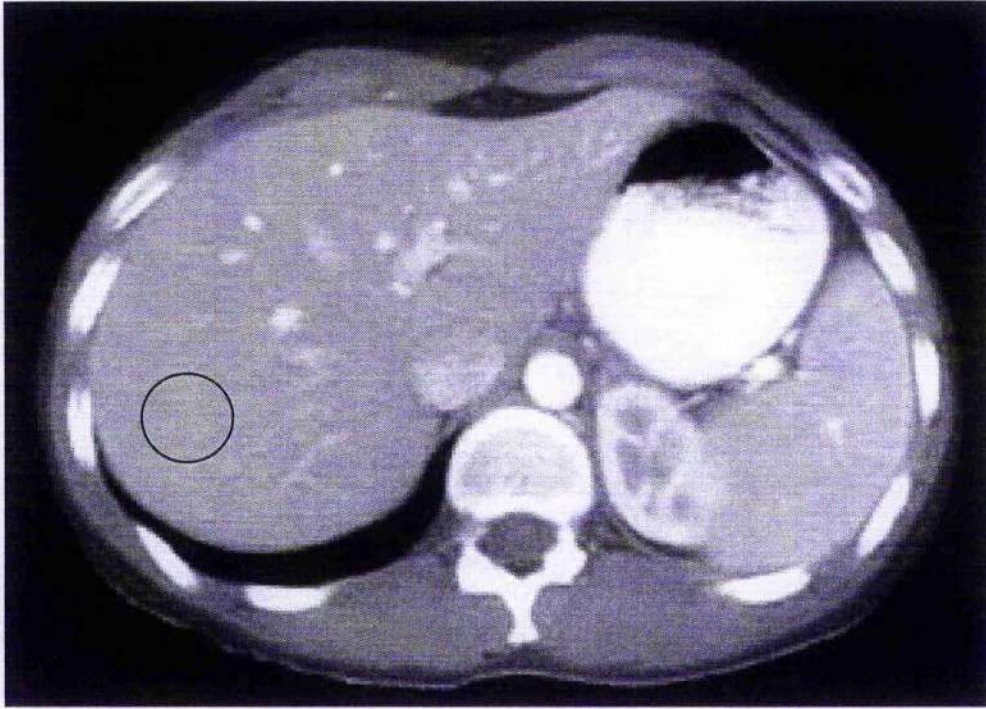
Figure B Dual-phase CT scan of abdomen, showing liver Region of Interest (ROI) for attenuation measurement.
